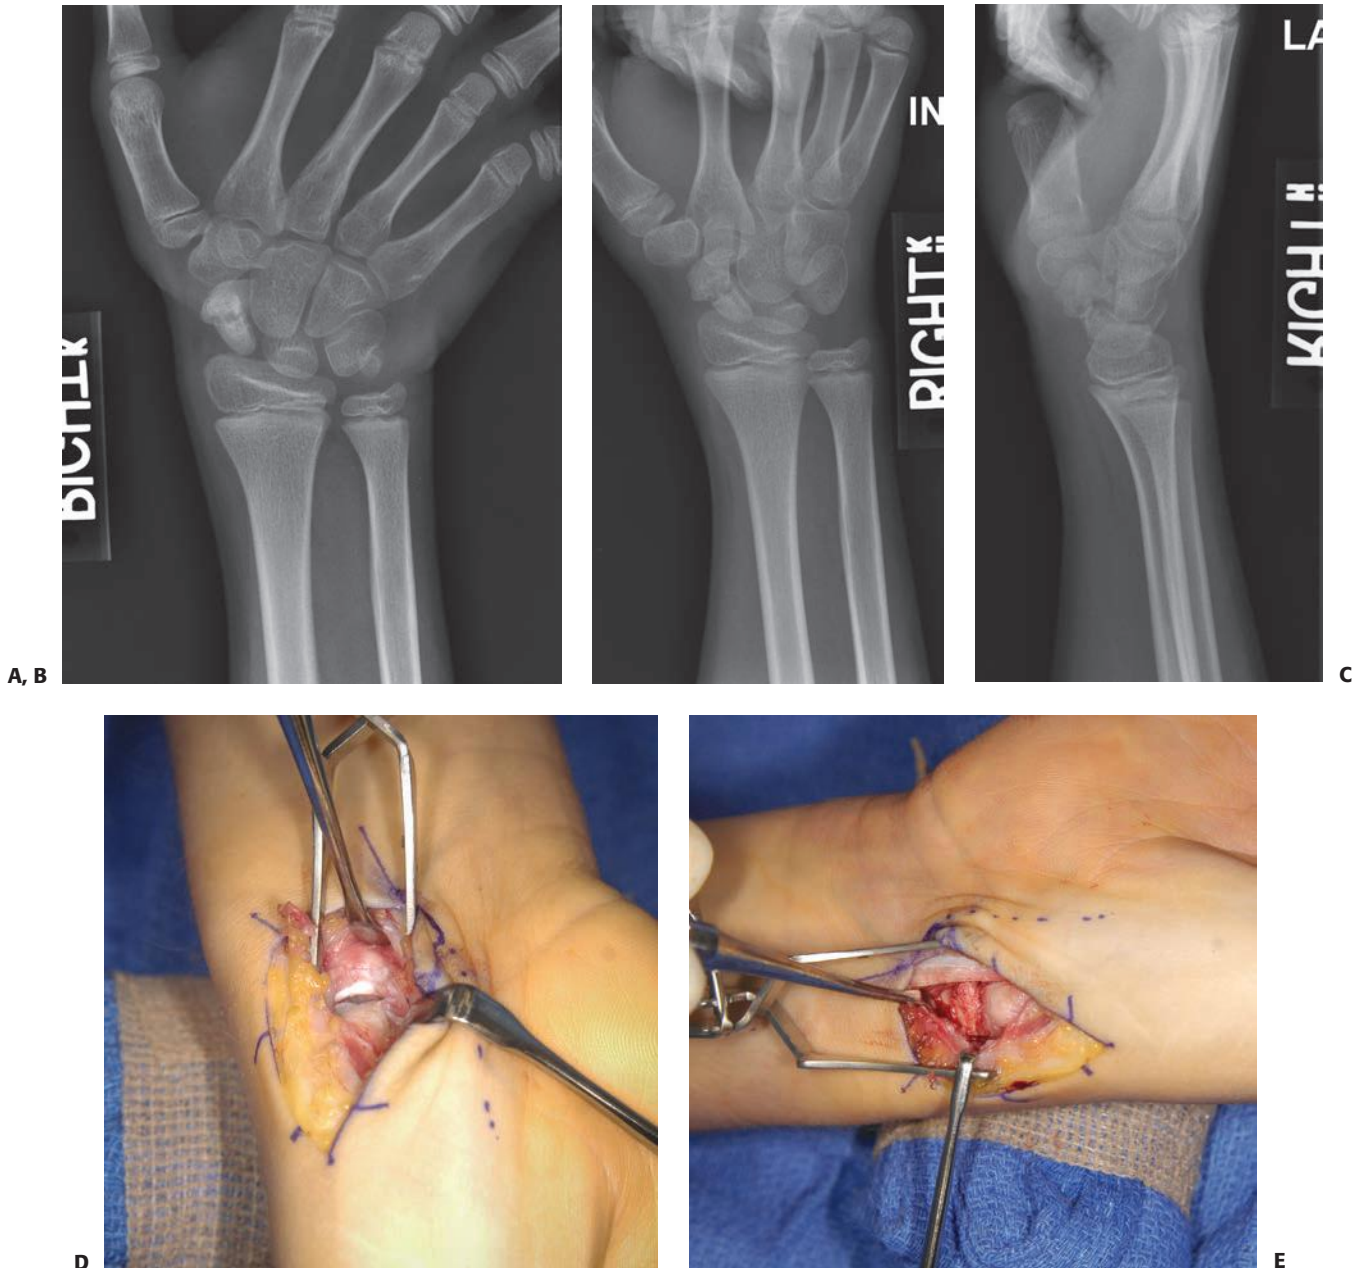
A–C: Radiographs of a 12-year-old boy with scaphoid nonunion and lunette extension through the fracture seen on the lateral view. D: Volar approach through the wrist to correct the mild humpback and flexion deformity. E: Iliac crest bone graft in place and headless screw fixation.
